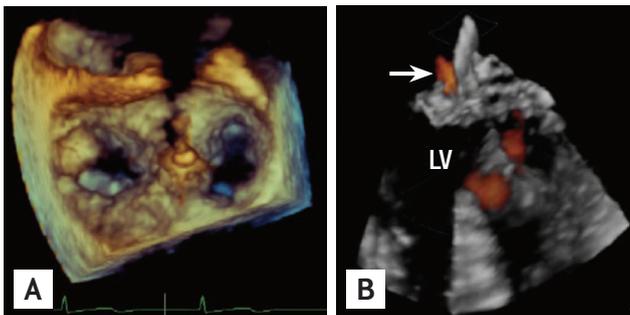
Mitral valve and residual small regurgitant jet (an arrow) imaged by 3-dimensional transesophageal echocardiography (A) without and (B) with color Doppler after clip procedure. LV, left ventricle.
